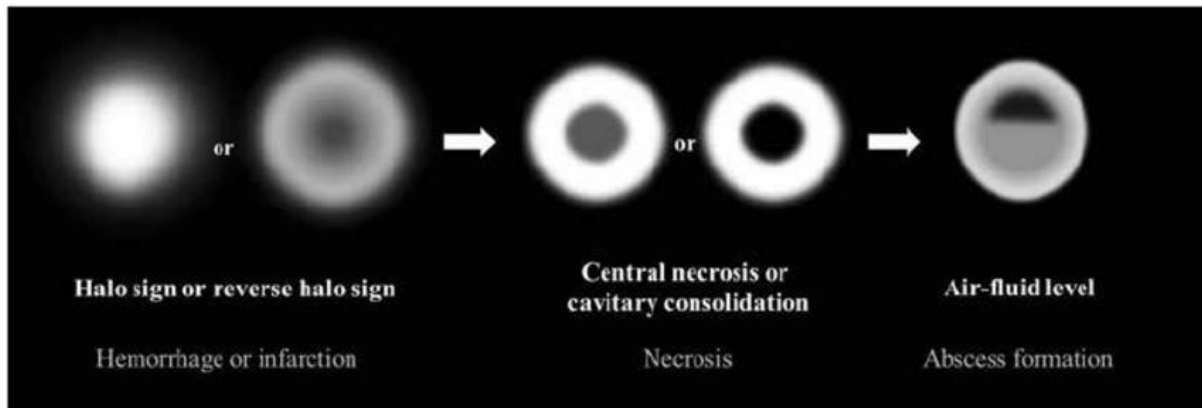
Initially, the halo sign on CT which represents focal consolidation with adjacent ground-glass opacity, develops due to hemorrhage caused by the angioinvasive characteristics. Thereafter, the reversed-halo sign may be seen. After disease progression, internal infarction causes central ground-glass opacity with peripheral consolidation. Necrotic or cavitory consolidation or masses may develop due to necrosis followed by abscess formation with an internal air-fluid line.<sup>23</sup>
